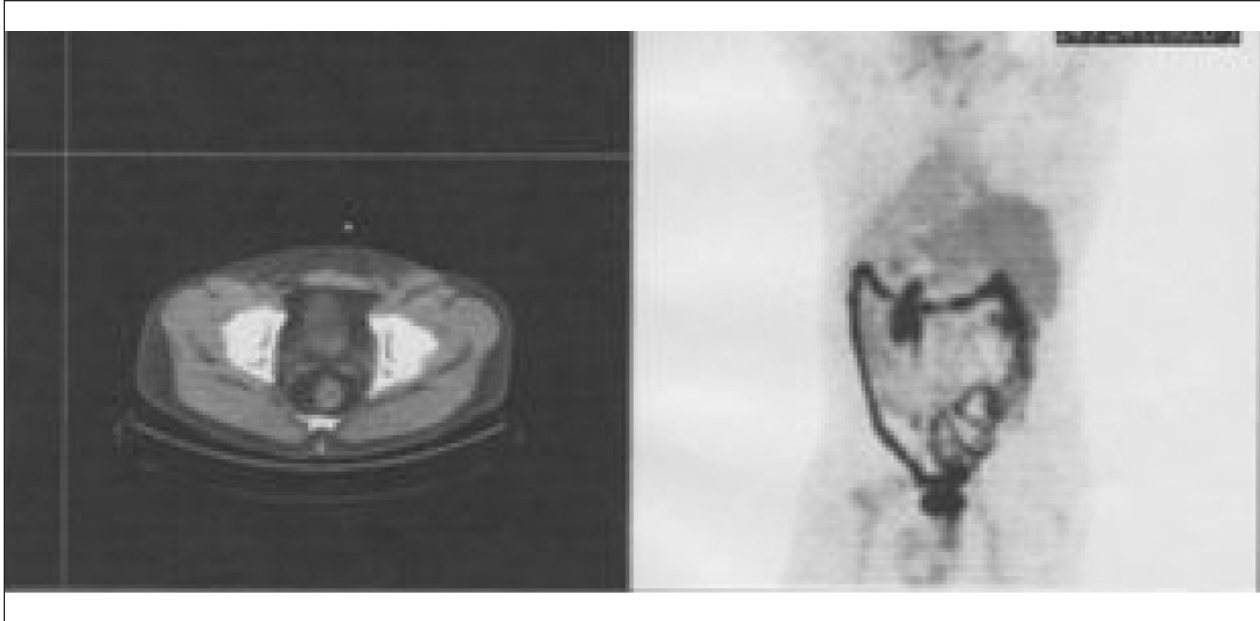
Computed tomography/positron emission tomography scans of May 16, 2006, demonstrate significant interval improvement of disease as compared with those of December 13, 2005.
